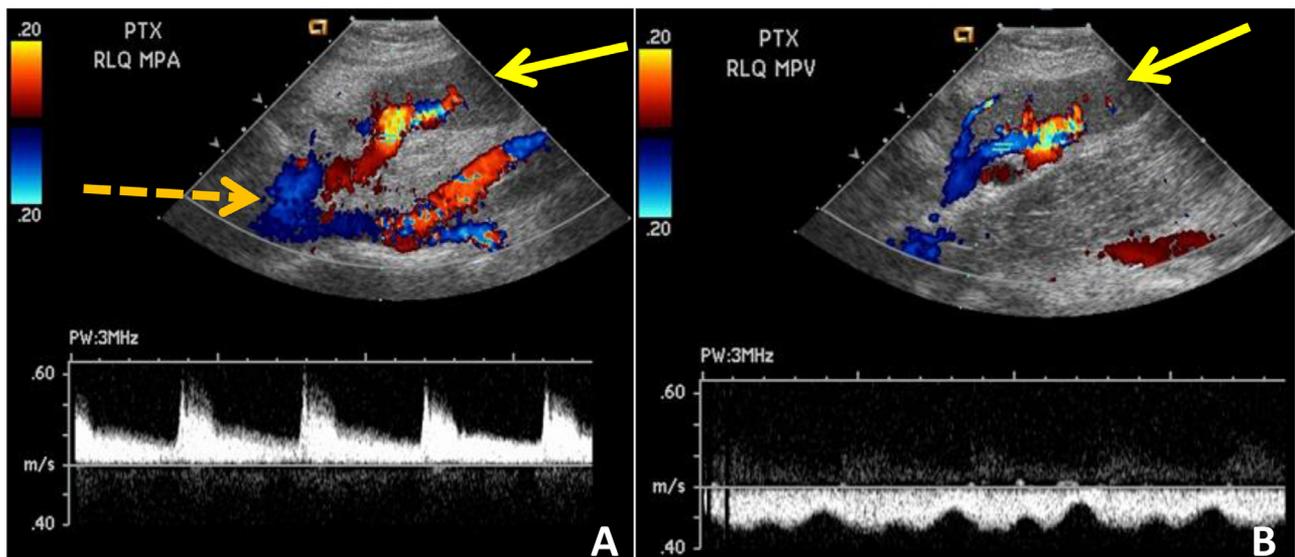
Arterial (Image A) and Venous (Image B) color Doppler images of the transplanted pancreas demonstrating normal arterial and venous wave forms in a 29-year-old female. Blood flow is noted to the normal sonographically appearing transplanted pancreas (solid arrow). The typical “Y-Graft” (dashed arrow) configuration is seen on arterial phase imaging.
